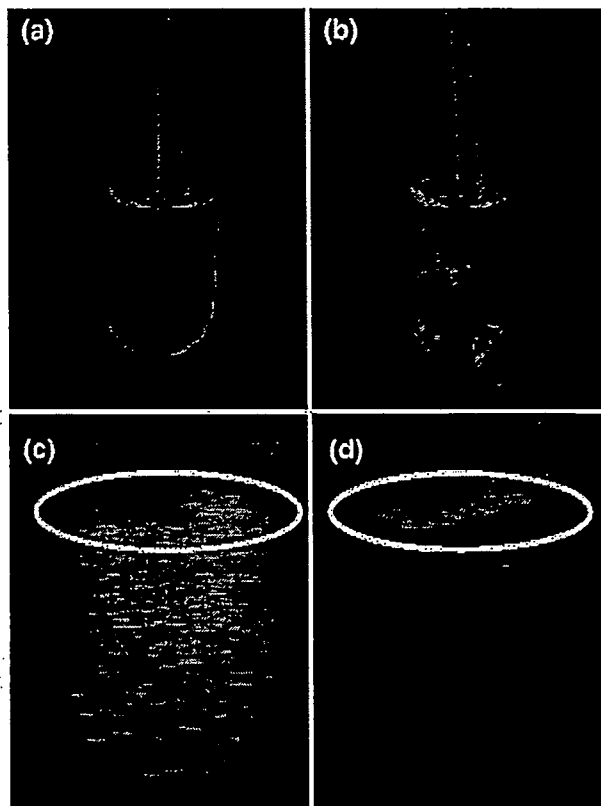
Cavitation of Bubble liposomes exposed to ultrasound. Naked (a, b) and ultrasonographic (c, d) images of Bubble liposomes. Ultrasonic probe (circle) positioned in Bubble liposome suspension exposed 2.5  $\text{W}/\text{cm}^2$  of ultrasound for 10 s. Images were observed before (a, c) and after ultrasound (b, d).
